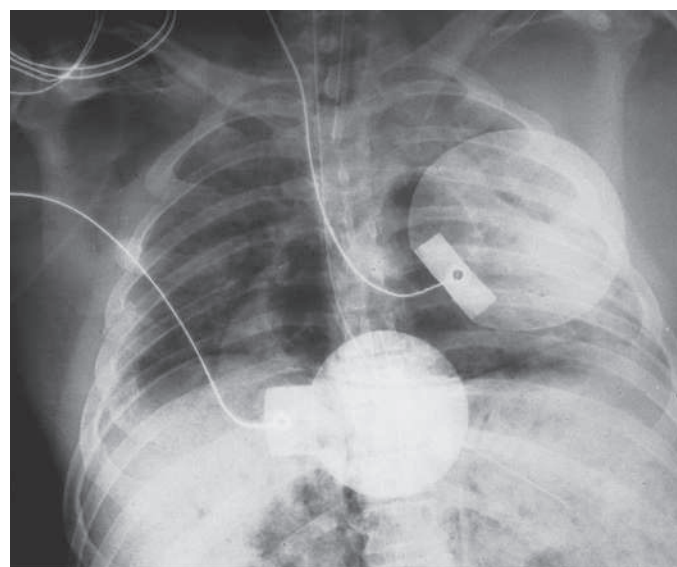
Chest radiograph of a diver who died suddenly from an arterial gas embolism, showing complete filling of the central vascular bed with air. Note the air in the heart and carotid arteries.
